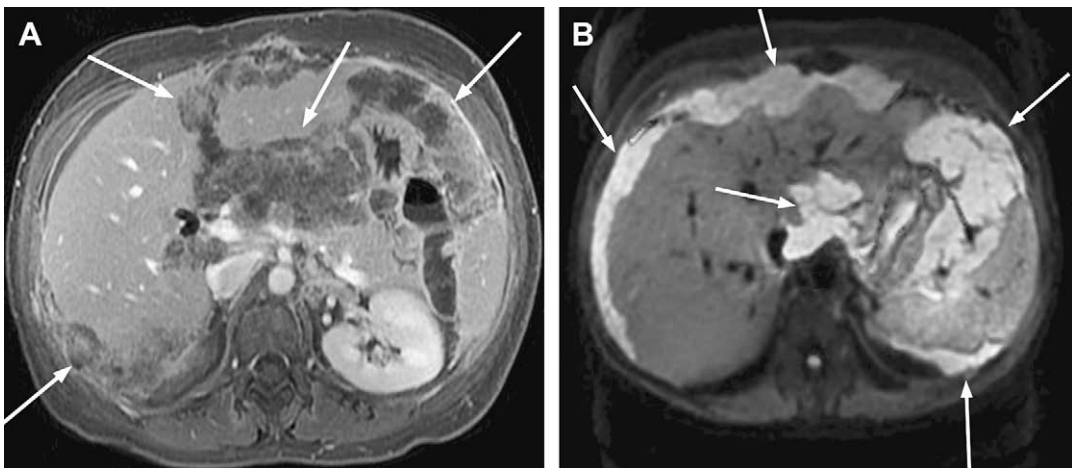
Patient with pseudomyxoma peritonei. Delayed gadolinium enhanced SGE MR image (A) depicts bulky upper abdominal peritoneal tumors (arrows) encasing the liver, spleen, stomach, and pancreas. Breath hold DW image (B) b value 400 s/mm² depicts bulky upper abdominal peritoneal tumors (arrows) showing restricted diffusion. Ascites is low signal intensity on DW images while tumors are high signal intensity.
